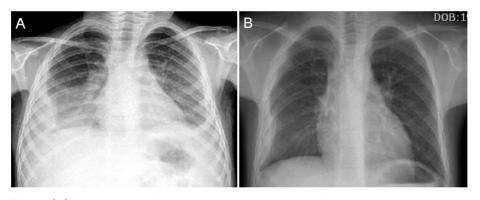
(A) Initial chest radiograph shows bilateral pleural effusions and right lower lobe consolidation in Case 1. (B) After 8 months, follow-up chest radiograph shows remaining small amount of right-sided pleural effusion with thickening.
